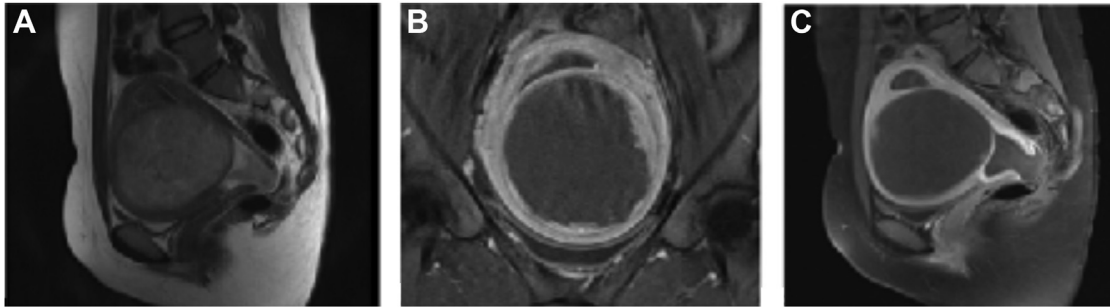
(A) T2-weighted sagittal magnetic resonance image of pelvis, demonstrating uterine mass with central necrosis. Coronal (B) and sagittal (C) T1-weighted magnetic resonance image of the pelvis, with heterogeneous signal and ring enhancement along periphery.
